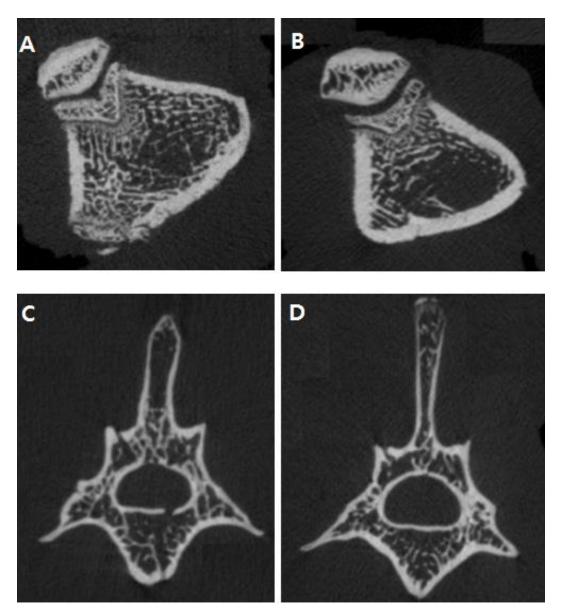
Micro CT axial images of femur and lumbar
